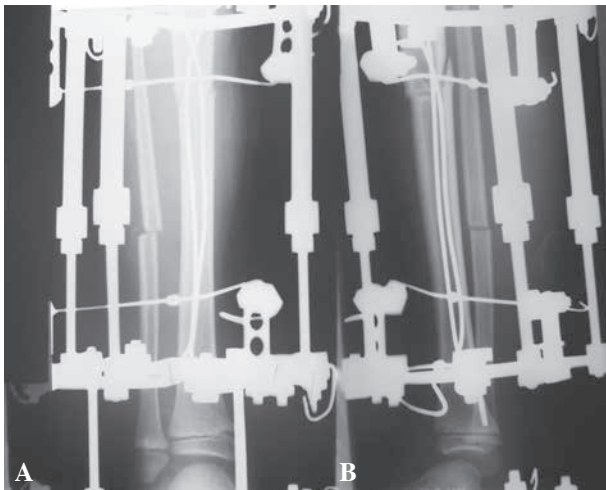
Combined technique. A) AP radiograph. B) Lateral radiograph.
